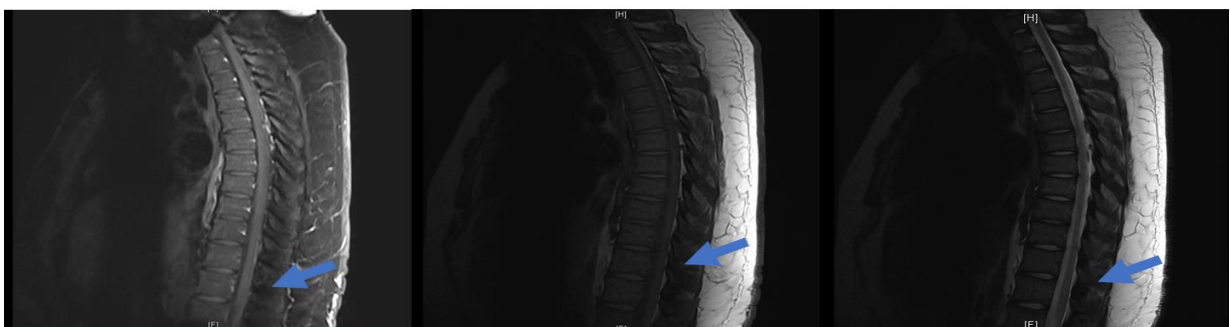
MRI Thoracic with contrast on thirteen day. It showed reduction in size of spinal epidural collection
